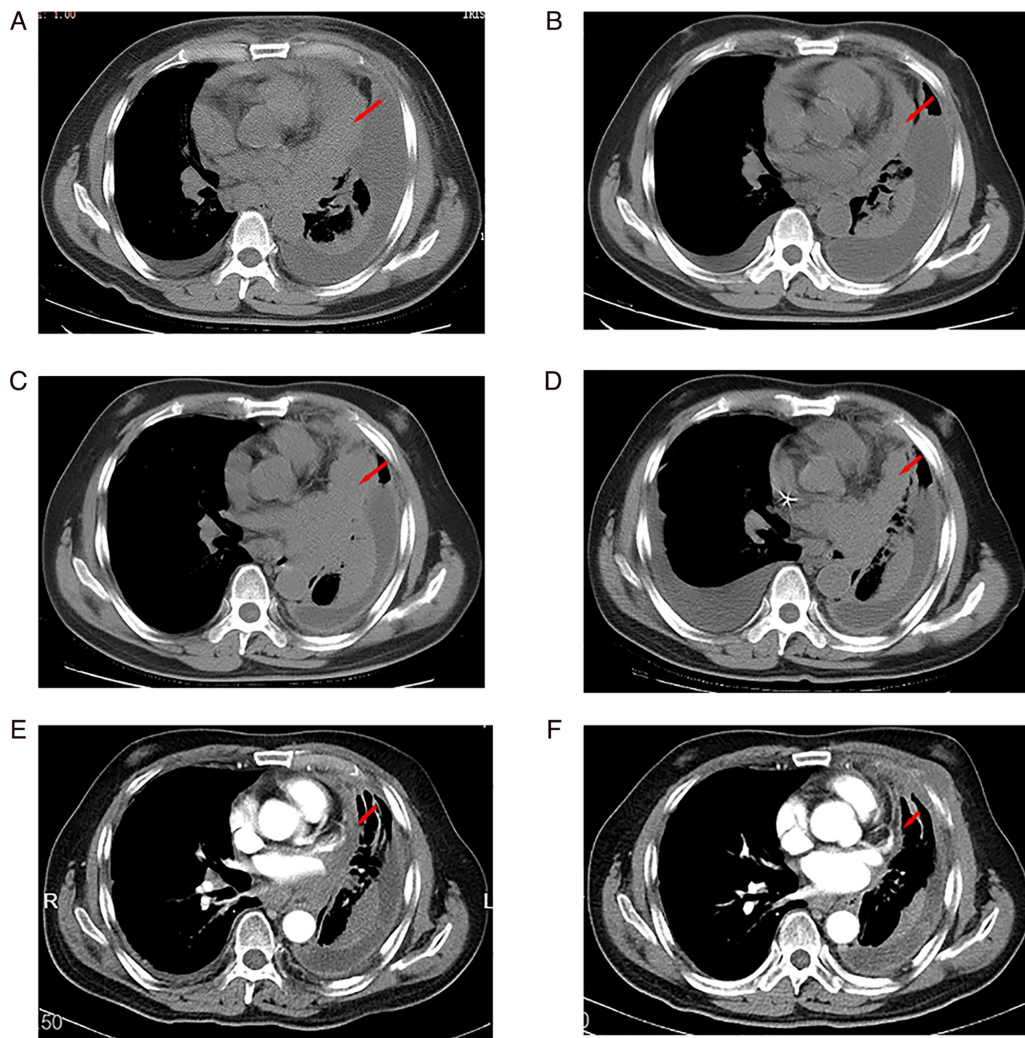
Chest CT images of the primary lung lesion (red arrows) at different time points. (A) Baseline image of a ~37 mm wide arc-shaped irregular mass in the left lung invading the left hilar region and mediastinum (6 February 2020). (B) Following two cycles of etoposide and carboplatin treatment the tumour was reduced to ~17 mm wide (28 March 2020). (C) Relapse of the primary lesion (width, ~37 mm; 19 November 2020). (D) After three cycles of irinotecan and cisplatin treatment, the tumour was reduced to ~27 mm wide (3 March 2021). (E) Following two cycles of toripalimab combined with anlotinib a partial response was achieved (~11 mm wide lesion; 20 April 2021). (F) Follow-up showed a partial response (~6 mm wide lesion; 13 November 2022).
